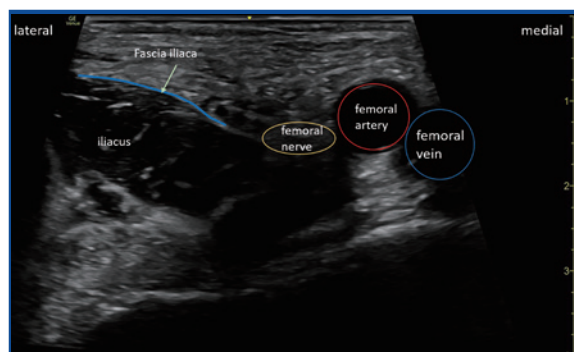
Sonographic anatomy of the fascia iliaca block (Ultrasound image and annotation by author)
